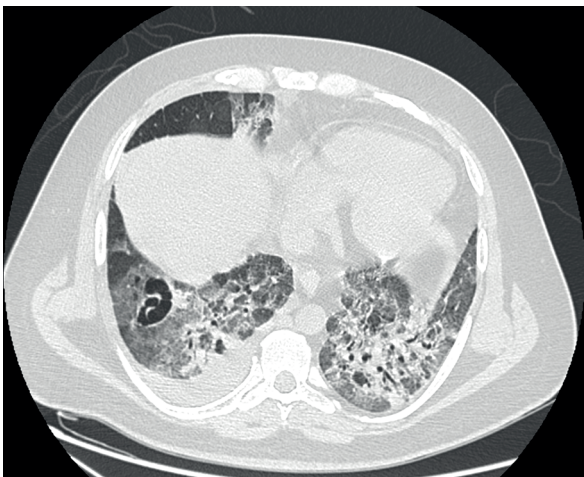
Multiple diffuse GGOs and consolidations with atol signs and crazy paving pattern in a 35 y.o. man hospitalized at ICU with respiratory failure – CT at day 29 after PCR diagnosis of Covid-19. Note the formation of lung cavities in the right lower lobe with numerous air bubble signs on the left side.
